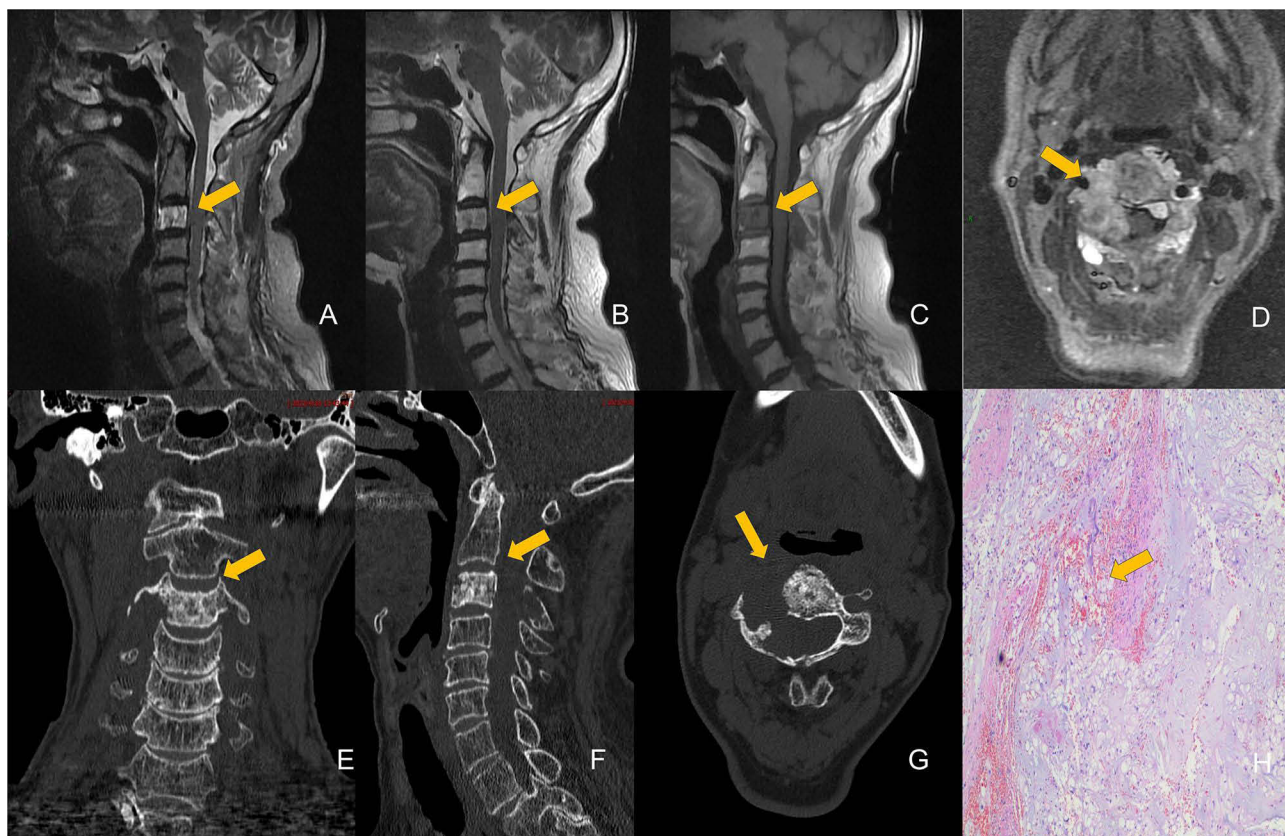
Chordoma of the C3 Vertebral Body, Female, 70 years old, with neck and shoulder pain for 1 week. (A) Fat-suppressed T2WI sagittal view shows the C3 vertebral body with intermediate and high signal intensity. (B and D) T2WI sagittal and axial views show the lesion with intermediate and high signal intensity. (C) T1WI sagittal view shows the lesion with intermediate signal intensity. (E–G) CT scan without contrast shows the lesion with expansile, lytic bone destruction, with sclerosis within the lesion. (H) HE ($\times 10$) shows that a large number of vacuolated cells (arrow) with hemorrhage.
